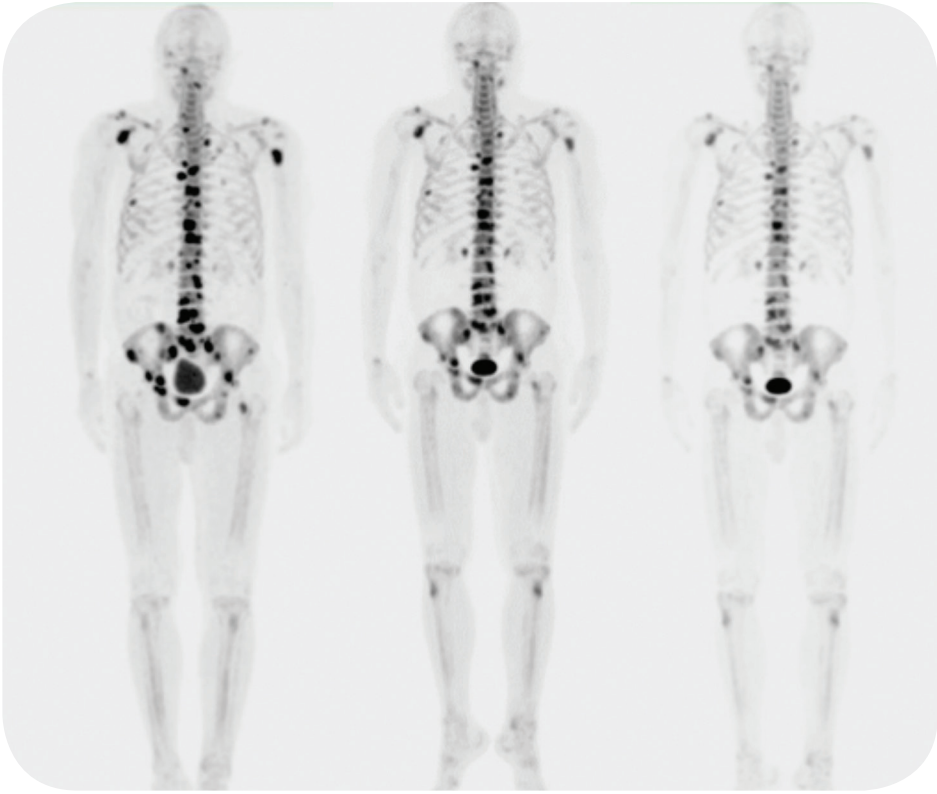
(a) PET/CT basal study using 18-NaF. (b) PET/CT with 18F-NaF following the administration of two 223Ra doses, (c) PET using 18F-NaF following the administration of four 223Ra doses.
